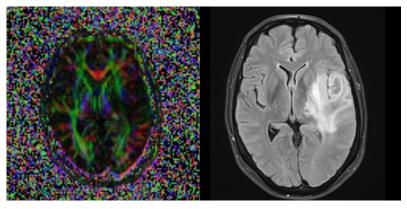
High Grade Glioma, left fractional anisotropy FA, right accompanying FLAIR sequence.
